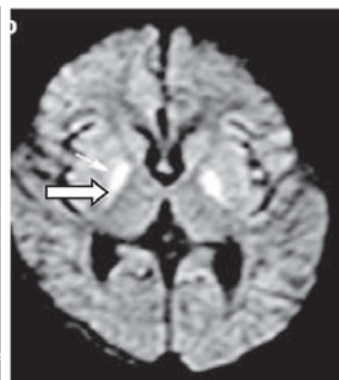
Propionic acidemia DWI showing diffusion restriction in both globus pallidi
